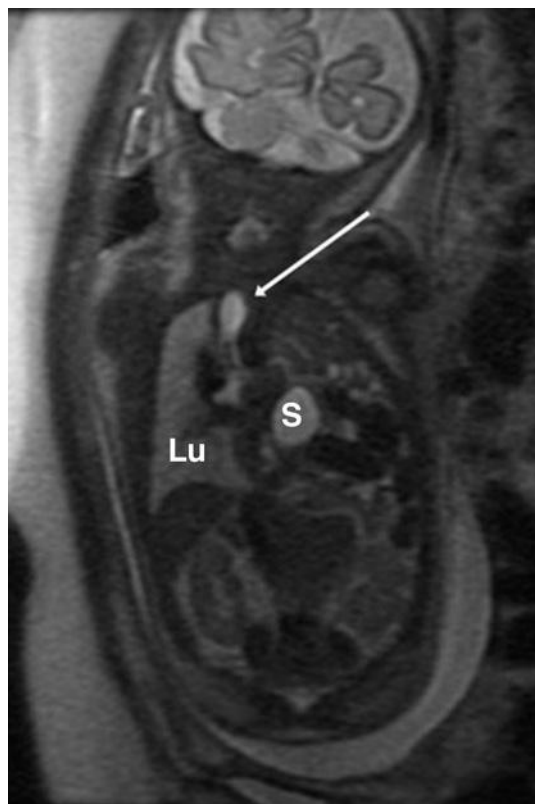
Coronal T2-weighted magnetic resonance imaging of fetus with large left congenital diaphragmatic hernia. Stomach (S) and bowel are shown within the left hemithorax. Fetoscopic intervention had been performed with placement of fluid-filled balloon (arrow) within the fetal trachea. Lu, right lung.
